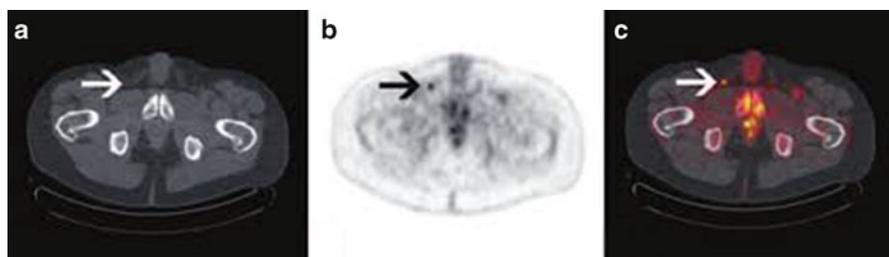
Suspicious inguinal node detected on 18F-fluorodeoxyglucose positron emission tomography-computed tomography in a high-risk cancer. (a) CT image; (b, c) Contrast image
